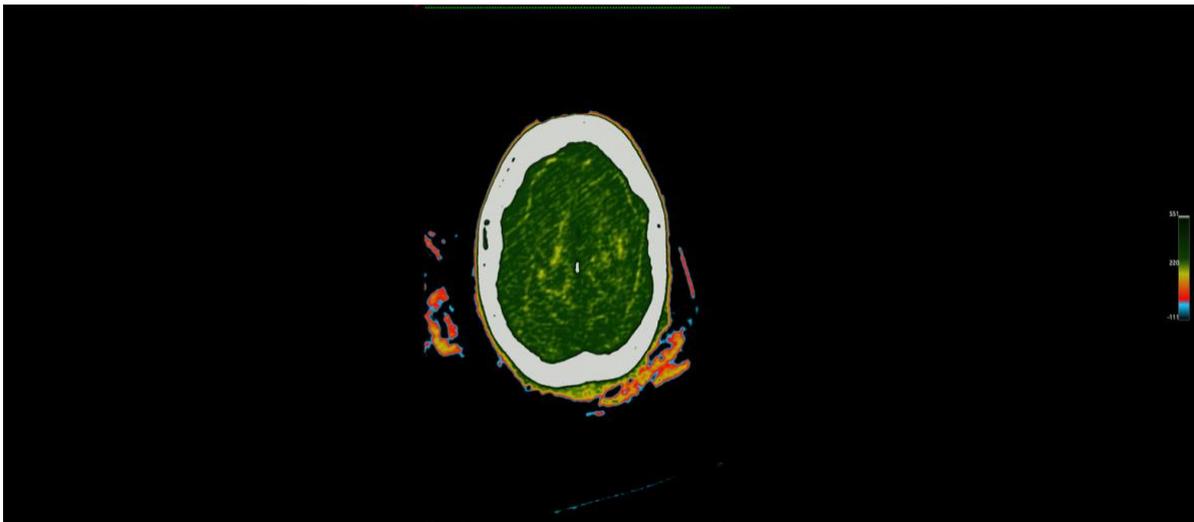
Axial plane CT slice 1.
